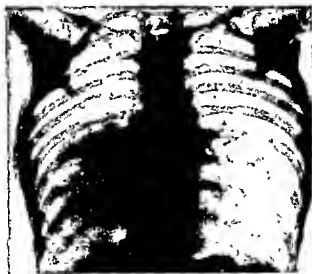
X-ray of a girl aged ten years, showing a large interlobar collection of pus on the right side. Note the absence of any displacement of the heart or trachea. The case is described on p. 377.
